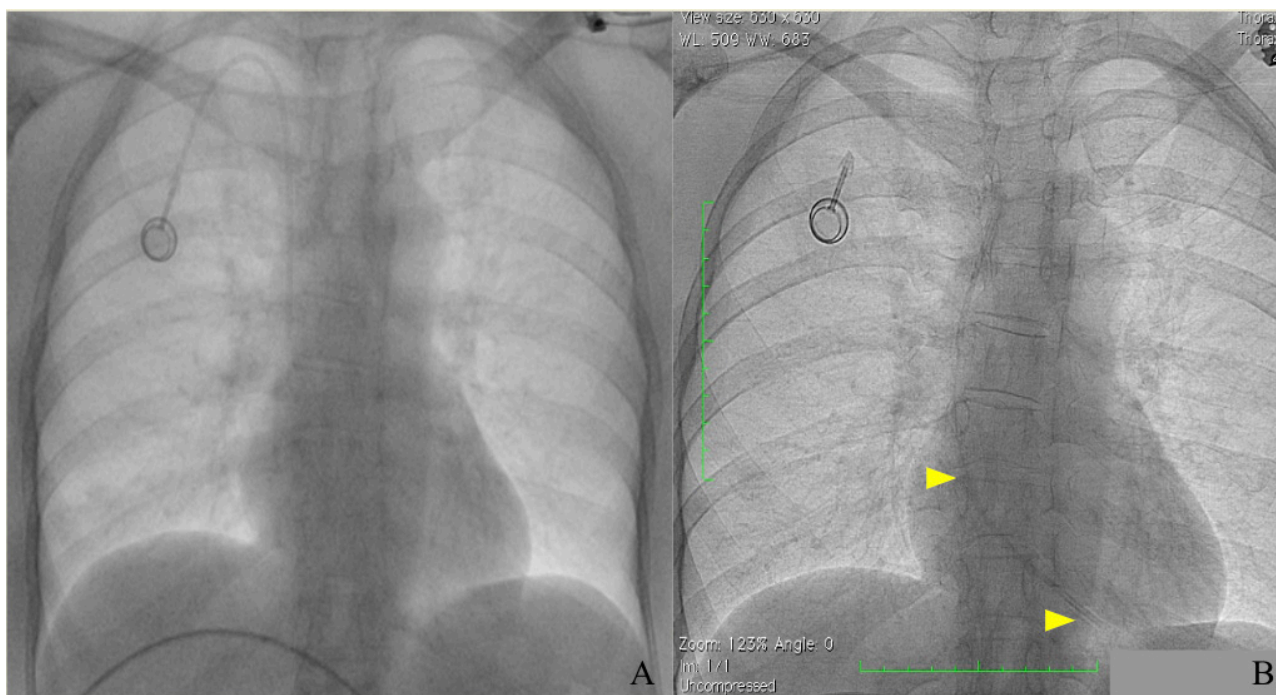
(A) Preliminary chest radiograph with chemoport in situ. (B) Yellow arrowheads denote the dislodged chemoport catheter.
